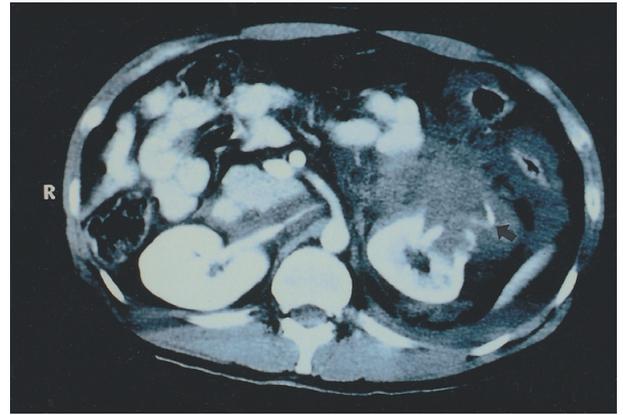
CT scan shows leakage of contrast dye from the upper outer portion of the left kidney in the arterial phase and hematoma in the perirenal space (arrow).
